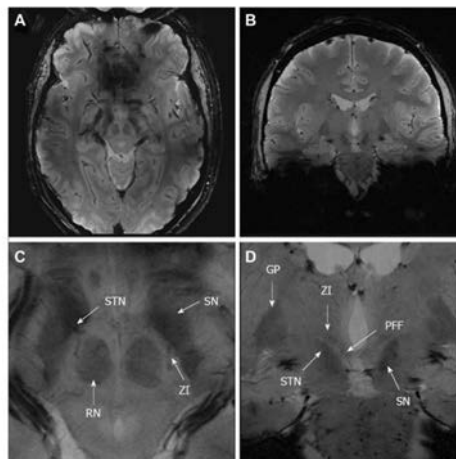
7 tesla MRI (FLASH2D-T2Star) of the subthalamic area, A. axial view and B. coronal view. C and D corresponding magnification displaying the labels of the structures of interest: STN: subthalamic nucleus; RN, red nucleus, SN, substantia nigra; ZI, zona incerta; GP, globus pallidus, and PPF, pallidofugal fibres. Modified from [35]
